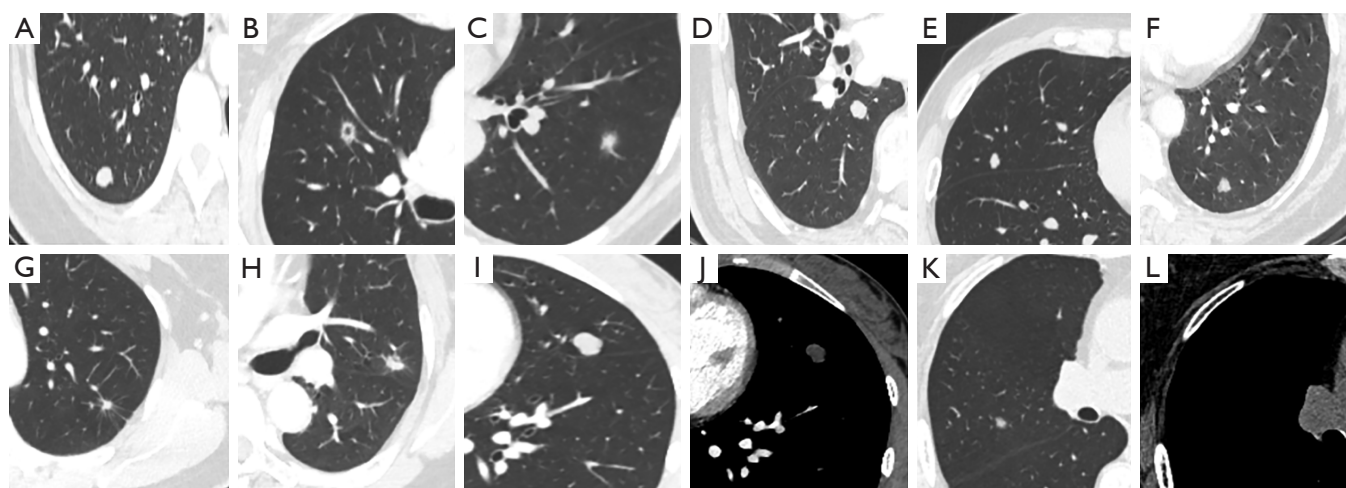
CT morphological characteristics and pathological subtypes of SSPNs. (A) A 38-year-old woman with no clinical symptoms. Axial CT scan shows 10.0 mm SSPN located in RLL, with clear and smooth tumor-lung interface. The nodule was pathologically confirmed as a chondroma by wedge resection. (B) A 58-year-old woman with no clinical symptoms. Axial CT scan shows 9.5 mm SSPN located in RUL, with clear and rough tumor-lung interface, short spiculation, vacuole. The nodule was pathologically confirmed as adenocarcinoma by lobectomy. (C) A 44-year-old woman, cough for more than 4 months. Axial CT scan shows 8.5 mm SSPN located in LLL, with unclear tumor-lung interface/halo sign. The nodule was pathologically confirmed to be adenocarcinoma by wedge resection. (D) A 55-year-old man with no clinical symptoms. Axial CT scan shows 9.5 mm SSPN located in RLL, with clear and smooth tumor-lung interface, shallow lobation. The nodule was pathologically confirmed as a chondromatous hamartoma by wedge resection. (E) A 63-year-old man with no clinical symptoms. Axial CT scan shows 7.5 mm SSPN located in RML, with clear and smooth tumor-lung interface, medium lobation. The nodule was pathologically confirmed as a hamartoma by wedge resection. (F) A 65-year-old woman with no clinical symptoms. Axial CT scan shows 7.5 mm SSPN located in LLL, with clear and rough tumor-lung interface and deep lobation. The nodule was pathologically confirmed to be adenocarcinoma by lobectomy. (G) A 52-year-old woman with no clinical symptoms. Axial CT scan shows 5.0 mm SSPN located in LUL, with clear and rough tumor-lung interface, long spiculation. The nodule was pathologically confirmed as fibroplasia by sublobar resection. (H) A 59-year-old man with no clinical symptoms. Axial CT scan shows 8.5 mm SSPN located in LUL, with clear and rough tumor-lung interface, deep lobation, air bronchogram and pleural traction. The nodule was pathologically confirmed as adenocarcinoma by sublobar resection. (I,J) A 27-year-old woman with no clinical symptoms. Axial CT scan shows 10.0 mm SSPN located in LUL, with clear and smooth tumor-lung interface, shallow lobation, visible at the mediastinal window (J). The nodule was pathologically confirmed as a chondromatous hamartoma by wedge resection. (K,L) A 67-year-old woman with no clinical symptoms. Axial CT scan shows 6.5 mm SSPN located in RUL, with unclear tumor-lung interface/halo sign tumor-lung interface, deep lobation, and invisible at the mediastinal window (L). The nodule was pathologically confirmed to be adenocarcinoma by lobectomy. CT, computed tomography; SSPNs, sub-centimeter solid pulmonary nodules; RLL, right lower lobe; RUL, right upper lobe; LLL, left lower lobe; RML, right middle lobe; LUL, left upper lobe.
